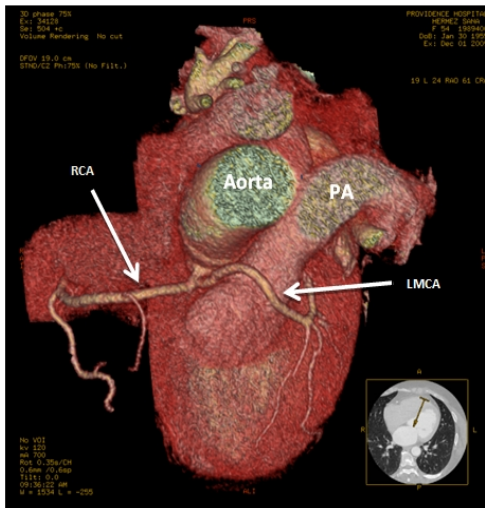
Volume rendering coronary CTA showing anterior course of the LMCA with respect to main pulmonary artery.
